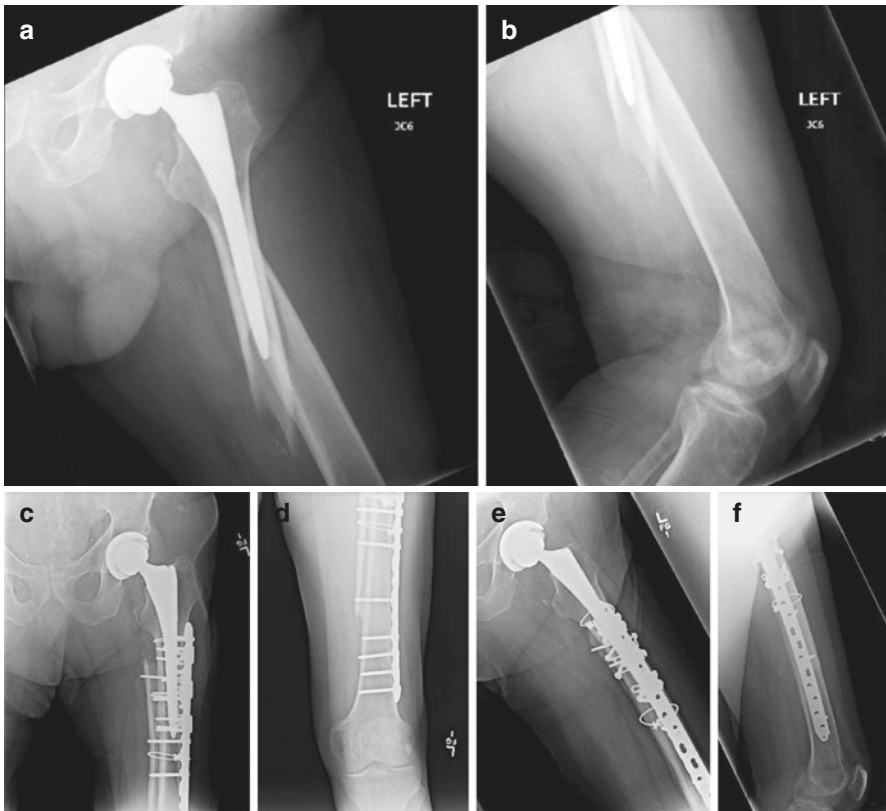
(a) Anteroposterior (AP) radiograph of an 81-year-old male patient with a history of left primary THA demonstrating a Vancouver Type C periprosthetic fracture which occurred after a ground-level fall; (b) lateral radiograph again demonstrating a Vancouver Type C periprosthetic fracture; (c, d) AP radiographs demonstrating open reduction and internal fixation (ORIF) of a Vancouver Type C periprosthetic fracture with a spanning plate, cerclage wires, and strut allograft; (e, f) lateral radiographs of the same patient again demonstrating ORIF of a Vancouver Type C periprosthetic fracture
